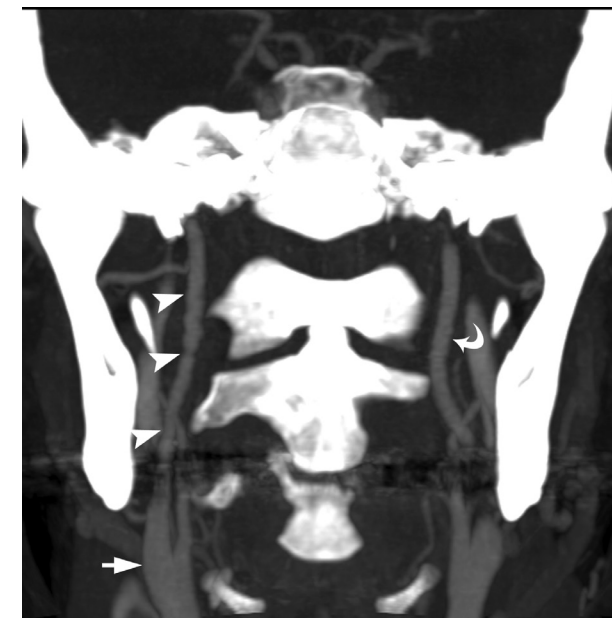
39-year-old woman with acute hemiparesis of left side of body and mild dysarthria. Coronally reformatted CT angiogram of right and left internal carotid arteries shows string-of-beads appearance of right internal carotid artery (arrowheads). Left internal carotid artery (curved arrow) is normal. Signs of atherosclerosis, especially at level of carotid bifurcation (straight arrow), are absent.
